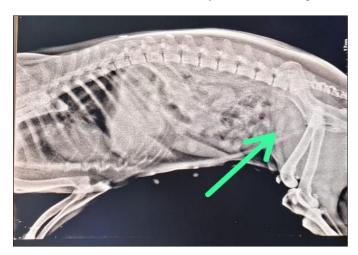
Radiograph showing indistinct uterine border and pelvic fat
